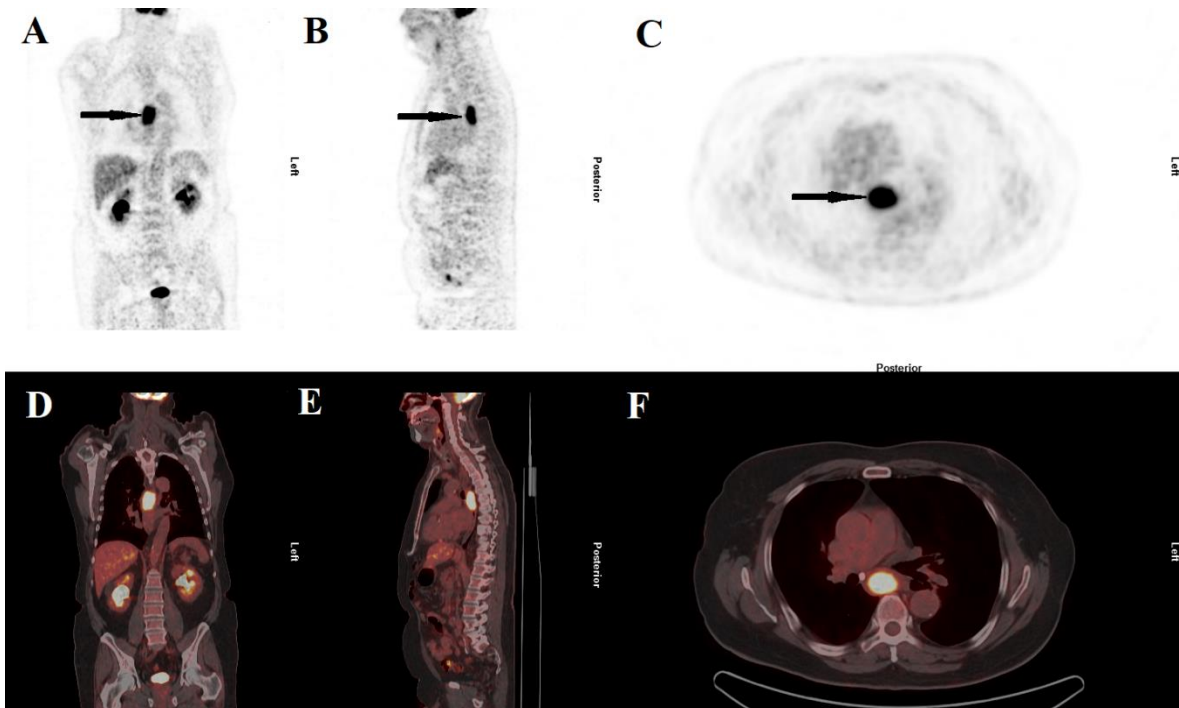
^{18}F FDG-PET/CT images of a 72-year-old male patient with a T3N1M0 squamous cell carcinoma of the middle oesophagus at baseline examination, preceding neoadjuvant chemo-radiotherapy. Images A-C consist of PET images in coronal, sagittal and transversal orientations. Black arrows indicate site of tumour FDG uptake. Images D-F are of fusion PET and CT images in the same orientations as above.
